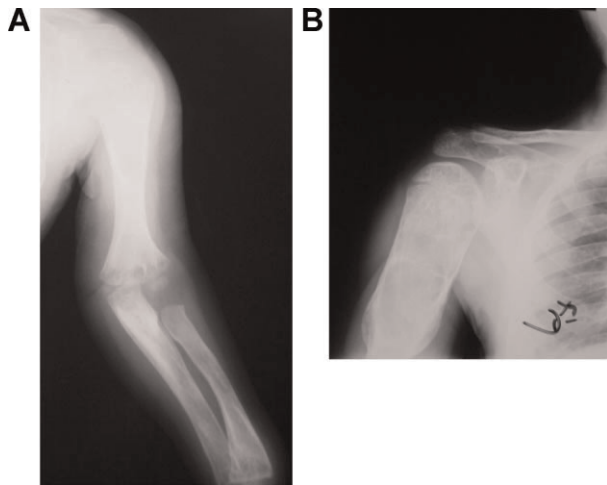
Radiograph of upper limb of the proposita at 3 years (A) and 11 years (B). Note the progressive widening and deformation of metaphyses and diaphyses, irregular trabeculation, and cystic changes. At 11 years the remnants of an old femur fracture are visible.
